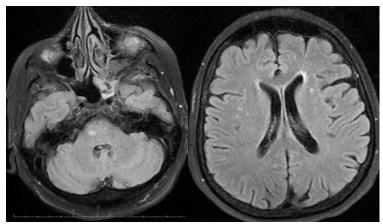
Axial fluid-attenuated inversion recovery (FLAIR) sequences demonstrating enhancement hyperintense appearance.
